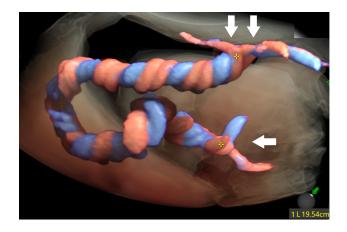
Subtle signs of congenital hypotonia on color Doppler imaging: short umbilical cord in case of minicore myopathy at 28 weeks' gestation. Cord measured < 20 cm from fetal end (arrow) to placental end (double arrows), i.e. $< 5^{\text{th}}$ centile.
